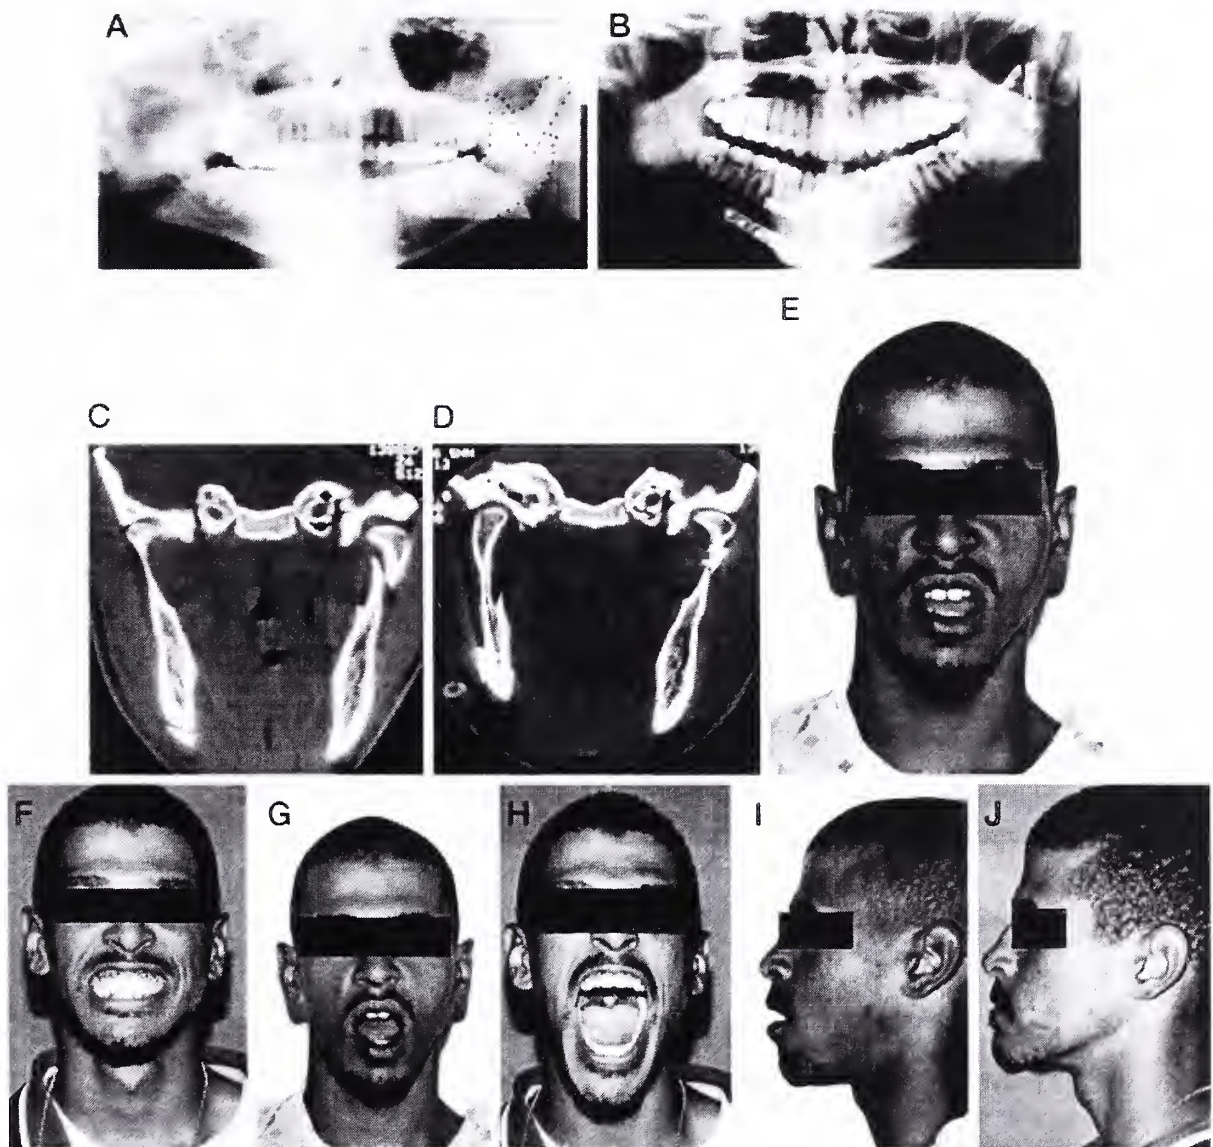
(A) Preoperative Panorex showing a left condylar neck fracture. The posterior mandibular height was shortened, and the proximal condylar segment was flexed. (B) Postoperative Panorex demonstrates correction of the flexed position of the proximal condylar fragment. (C) Preoperative coronal computed tomography demonstrated an extracapsular fracture with lateral override and shortening of the posterior mandibular height. The length of the extracapsular proximal fracture fragment was found to be sufficient to anchor proximal plate fixation screws. (D) After endoscopic repair, anatomic correction of the fracture was confirmed on the radiographs. The posterior mandibular height has been restored. (E) Preoperative frontal view with patient attempting to bring teeth into occlusion. (F) Postoperative occlusion. Preoperative restriction in jaw opening (G) restored after endoscopic repair (H). (I) Preoperative lateral facial view shows loss of chin projection in this patient with left mandibular condylar neck fracture. (J) Postoperative chin point and jaw line restored after left endoscopic condylar neck repair without postoperative maxillomandibular fixation.
